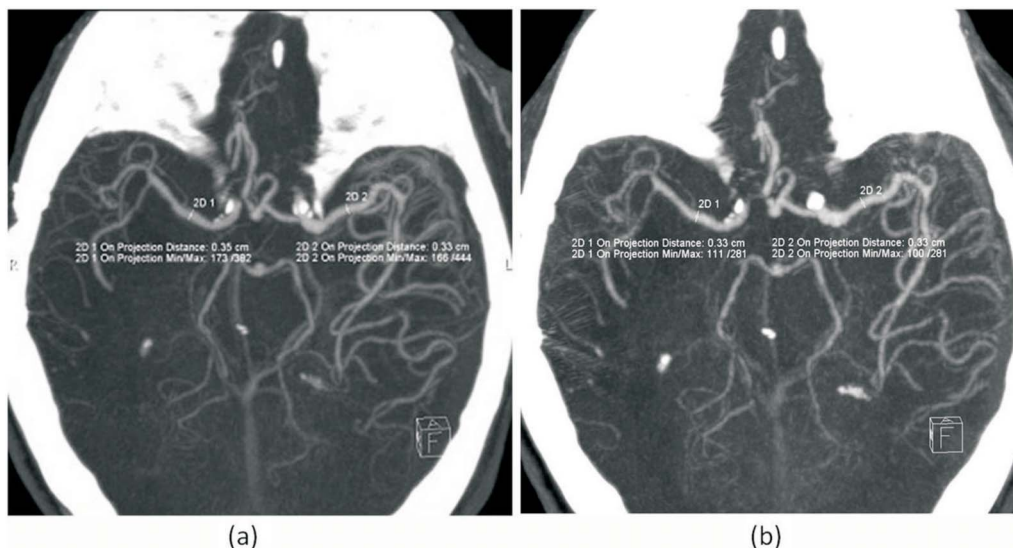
The representative computed tomography angiography images, (a) before operation; and (b) on the fourth day after operation.
